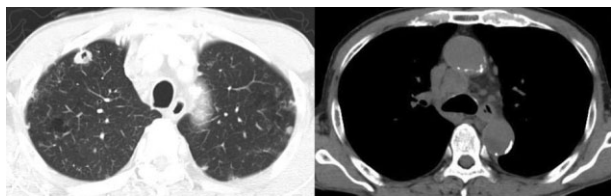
Chest computed tomography before endobronchial ultrasound-guided transbronchial needle aspiration. (Left panel) A nodule in the right upper lobe with thickened wall and cavitation was suspected as a primary lesion. Solid nodules in the left upper lobe were considered as metastases. (Right panel) Enlarged lower paratracheal lymph node (4R) was seen.
